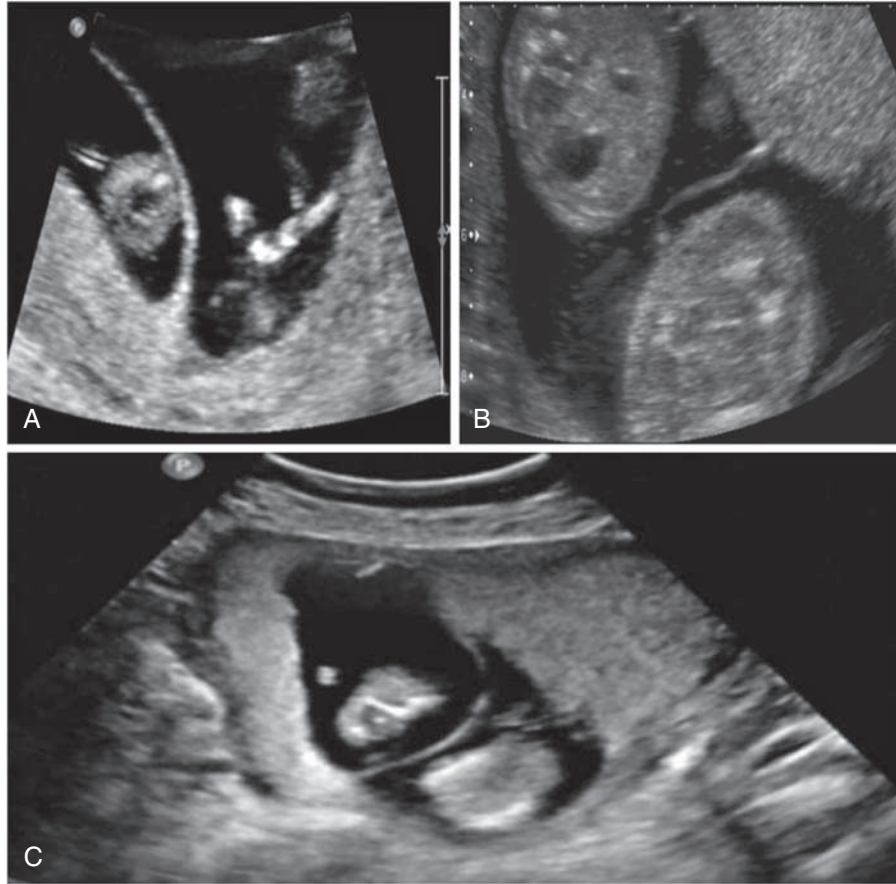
Ultrasound determination of chorionicity during first trimester. A: Lambda sign, B: T-sign, C: Two different placental masses.
